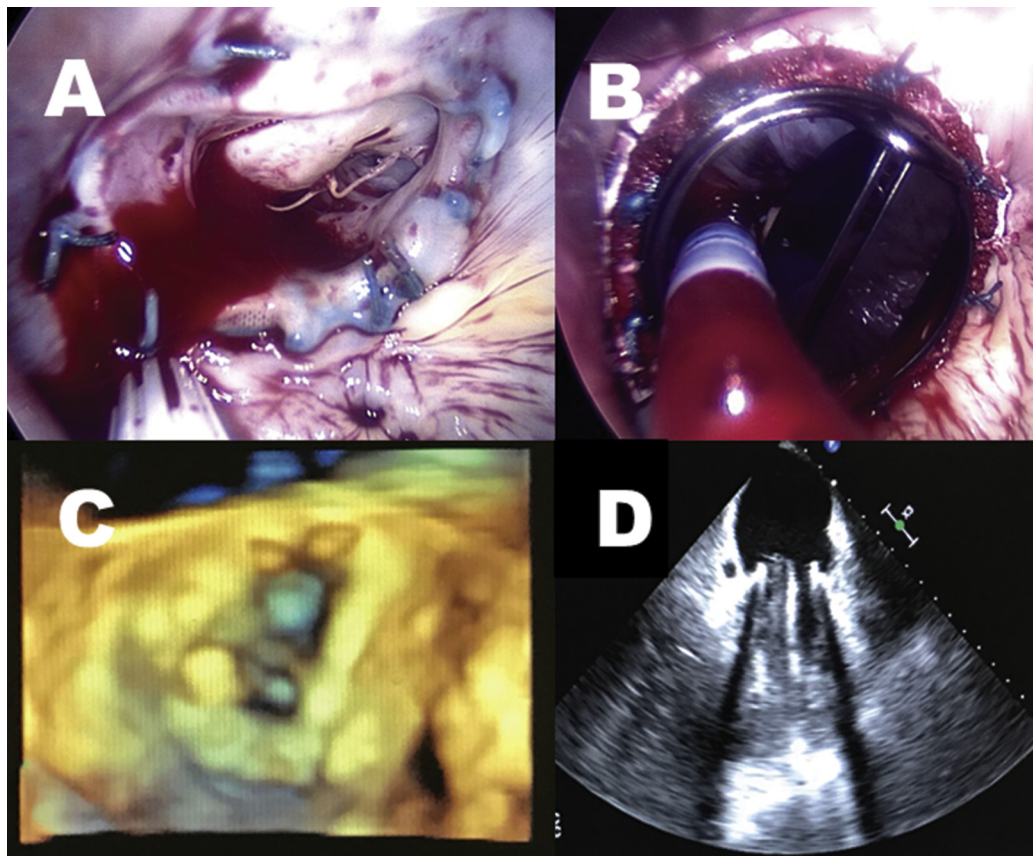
Intraoperative photographs and echocardiograms showing (A and C) a small and scarred native valve preoperatively and (B and D) a 23-mm Regent mechanical prosthesis in place postoperatively.
